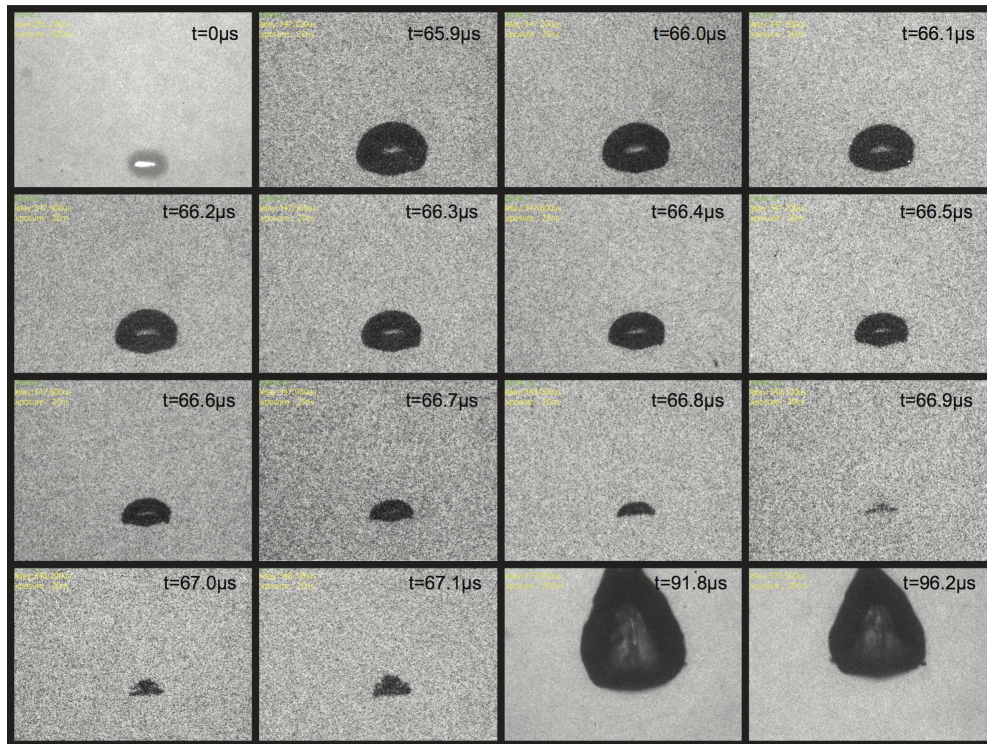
Highly temporally resolved collapse of jetting LIC - this figure represent observation around the moment of collapse for an LIC that jets, at 10 Mfps, under HIFU exposure. The flattening of the cavity wall exposed to the ultrasound is very apparent even around the moment of collapse. The first frame captured the plasma formation; the last two frames were triggered to capture the subsequent jetting.
